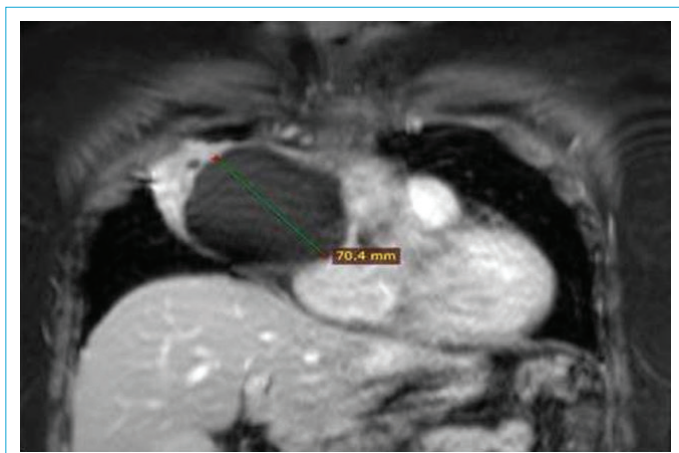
Paracardiac cystic mass (7 cm in diameter) on thorax MRI.
